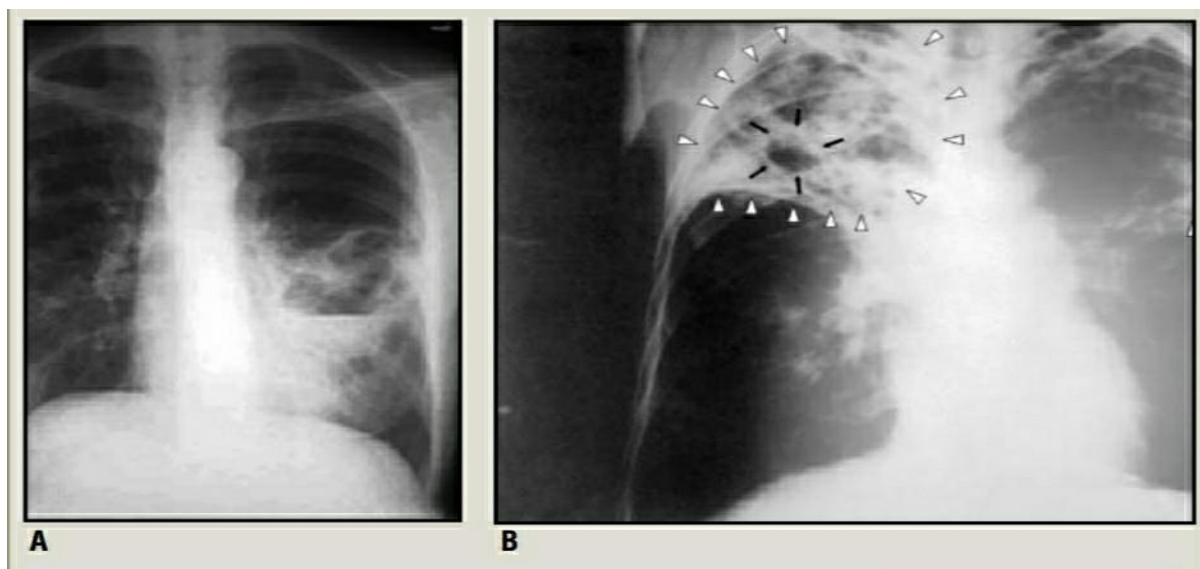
Chest radiographs in pulmonary tuberculosis. A, Infiltrates in left lung. B, Bilateral advanced pulmonary tuberculosis and cavitation in apical area of right lung.¹⁴
